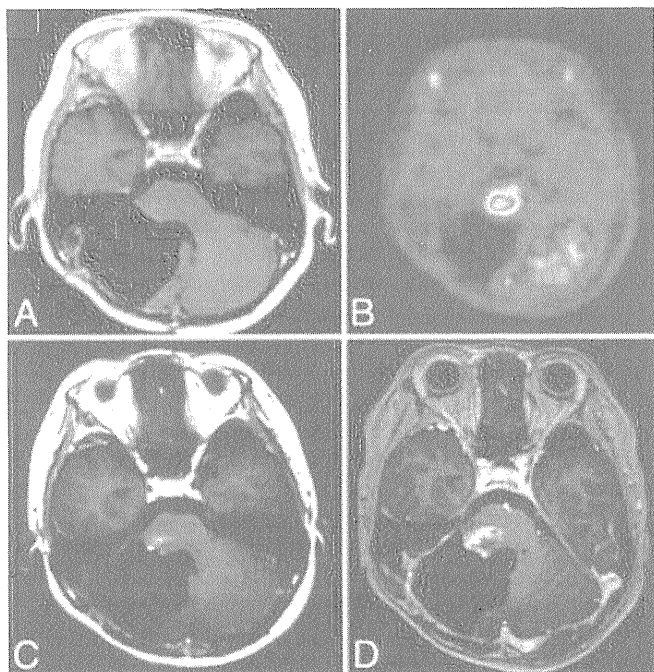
Axial contrast-enhanced T1-weighted MR images obtained in June 2009 when recurrence in the brainstem was suspected (A), 6 days later (C) obtained together with a methionine-based PET scan (B), and 16 days later just before treatment CED (D).
